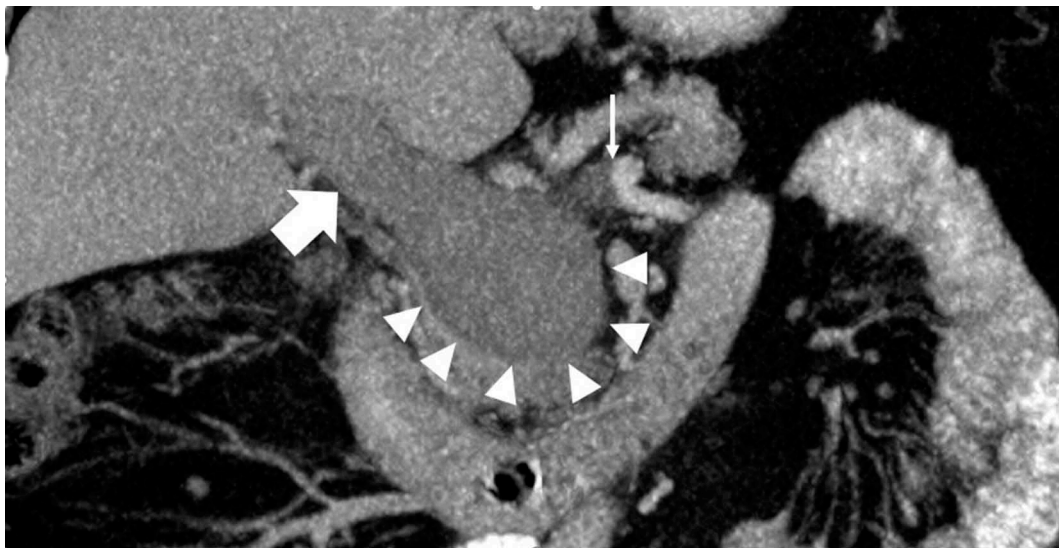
Contrast-enhanced CT image in the portal venous phase. Large thrombosed aneurysm of the splenomesenteric confluence (arrowheads) extending into the main portal trunk (thick arrow) and the splenic vein (thin arrow).
